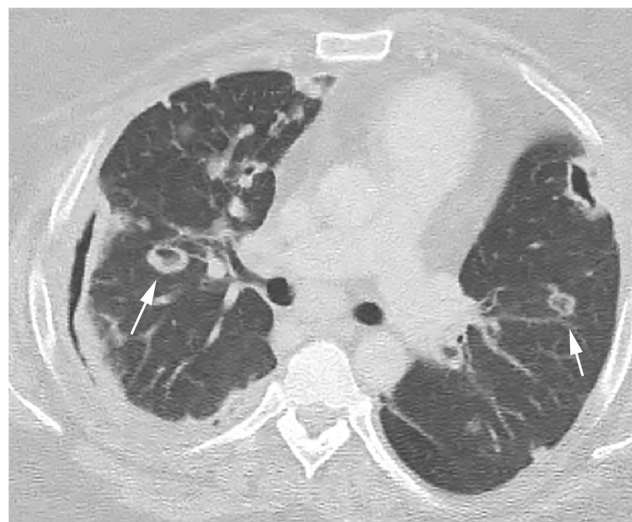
CT of a rheumatoid arthritis patient demonstrates multiple, bilateral pulmonary nodules, some of which show cavitation (*arrows*). Lung biopsy confirmed necrobiotic nodules. CT computed tomography
